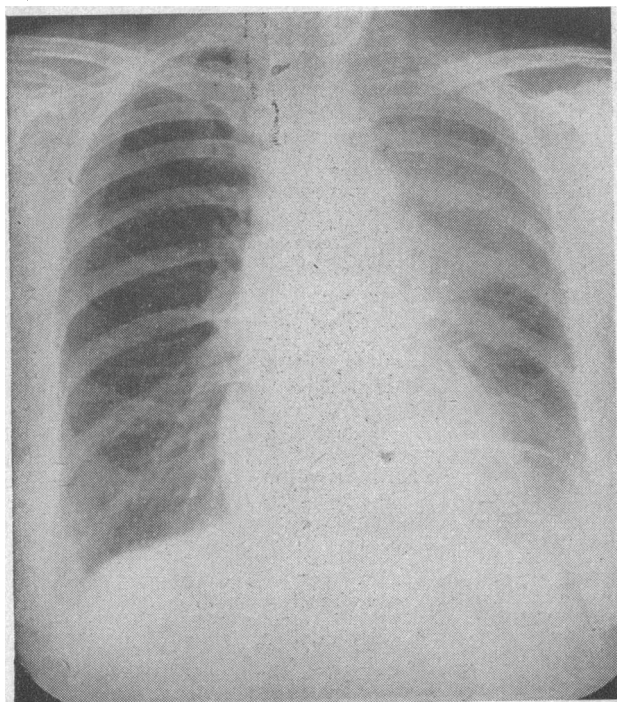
X-ray film taken on November 11, 1952, suggestive of a tumour involving the upper lobe of the left lung.
